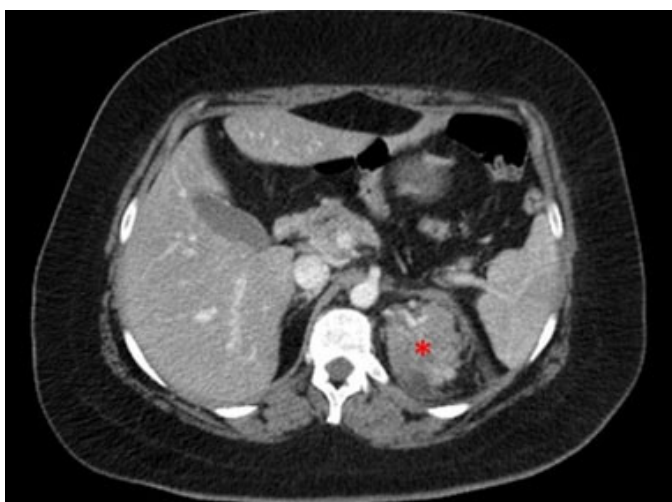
CT abdomen and pelvis with IV contrast axial view. Inflamed pancreatic tail that is herniated above the left hemidiaphragm shown in red asterisk.
